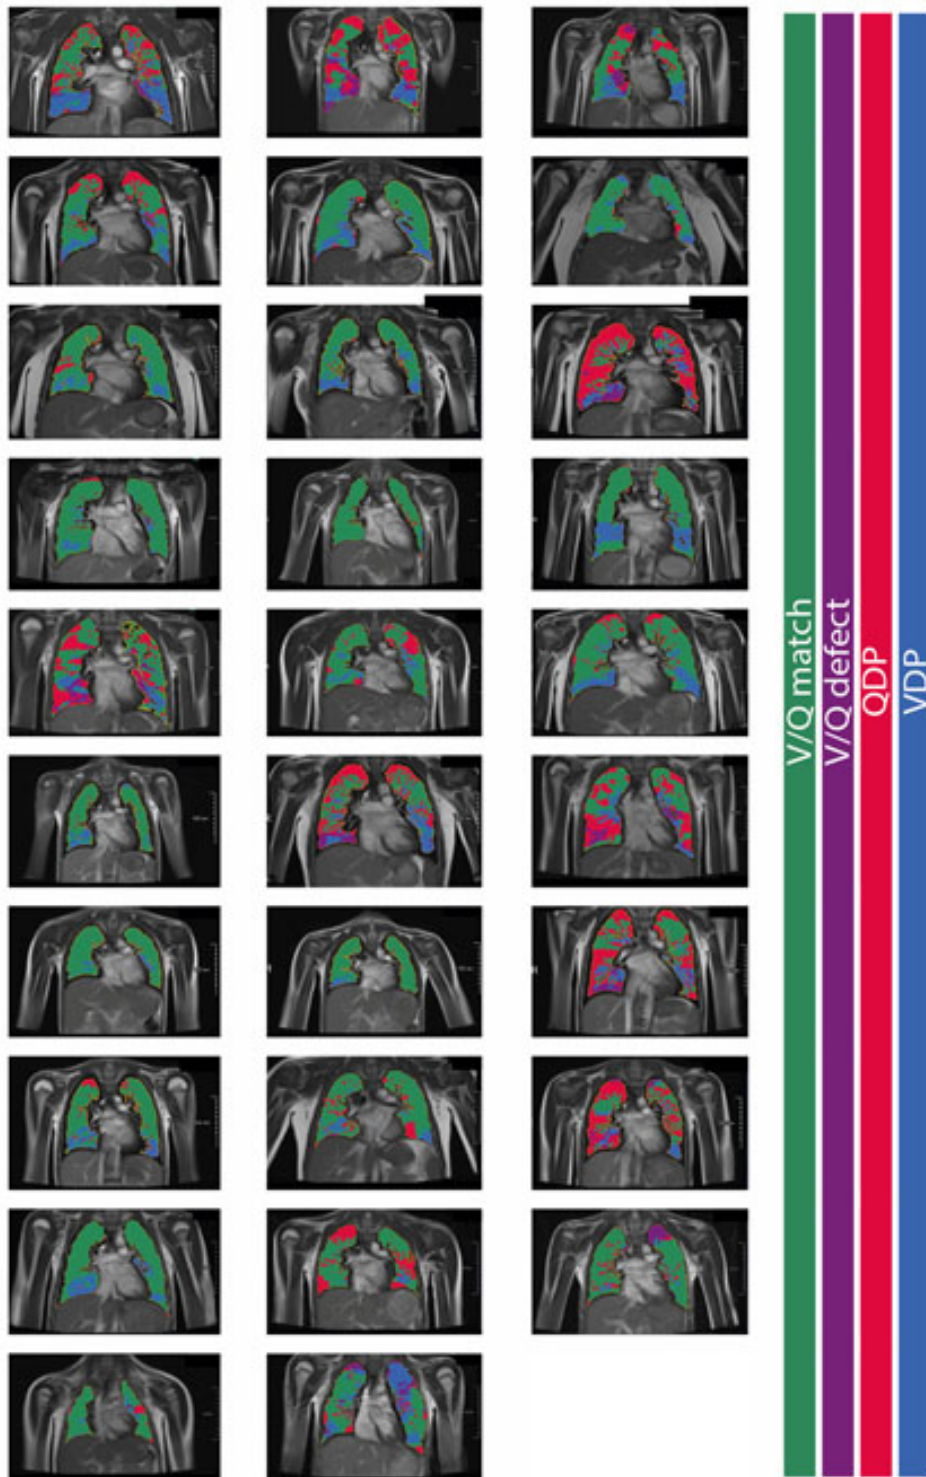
Free-breathing phase-resolved functional lung (PREFUL) low-field MRI with calculated parameters at an axial plane after automatic registration to a mid-expiration position and lung parenchyma segmentation in participants recovered from COVID-19.
